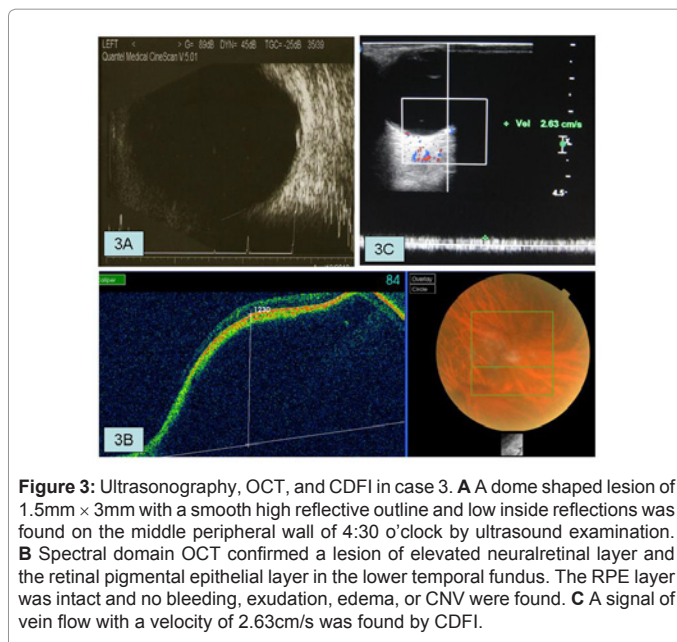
Ultrasonography, OCT, and CDFI in case 3. A A dome shaped lesion of 1.5mm × 3mm with a smooth high reflective outline and low inside reflections was found on the middle peripheral wall of 4:30 o'clock by ultrasound examination. B Spectral domain OCT confirmed a lesion of elevated neuralretinal layer and the retinal pigmental epithelial layer in the lower temporal fundus. The RPE layer was intact and no bleeding, exudation, edema, or CNV were found. C A signal of vein flow with a velocity of 2.63cm/s was found by CDFI.
